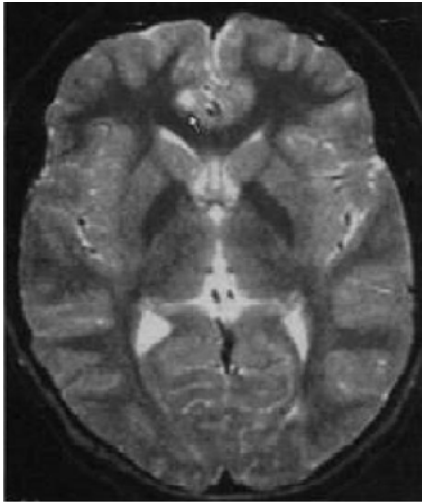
Infarcts in a 36-year old man with cerebral malaria. Hyperintense cortical areas (infarcts) seen on a fast spin-echo T2 weighted MR image (arrow) (Cordoliani et al 2004, with permission © American Society of Neuroradiology).⁵⁴
